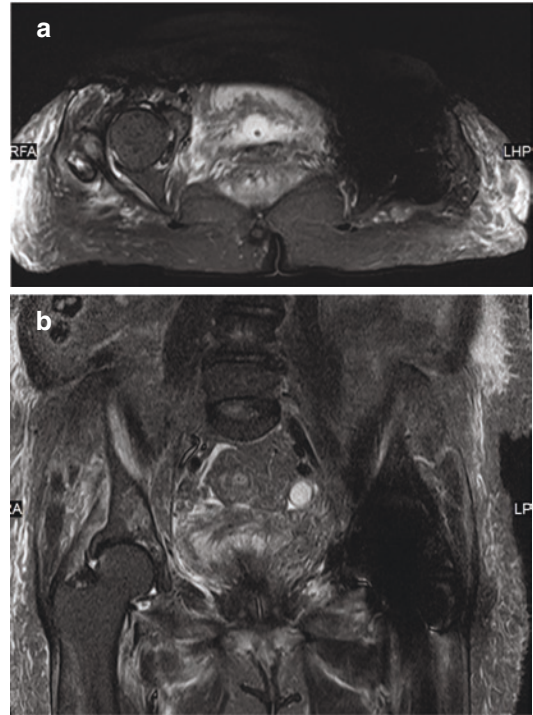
Susceptibility artifacts. (a) Axial and (b) coronal MR images of the pelvis show susceptibility artifacts due to a left hip prosthesis. The large area of signal void produced by the susceptibility artifact prevents assessment of the affected region
